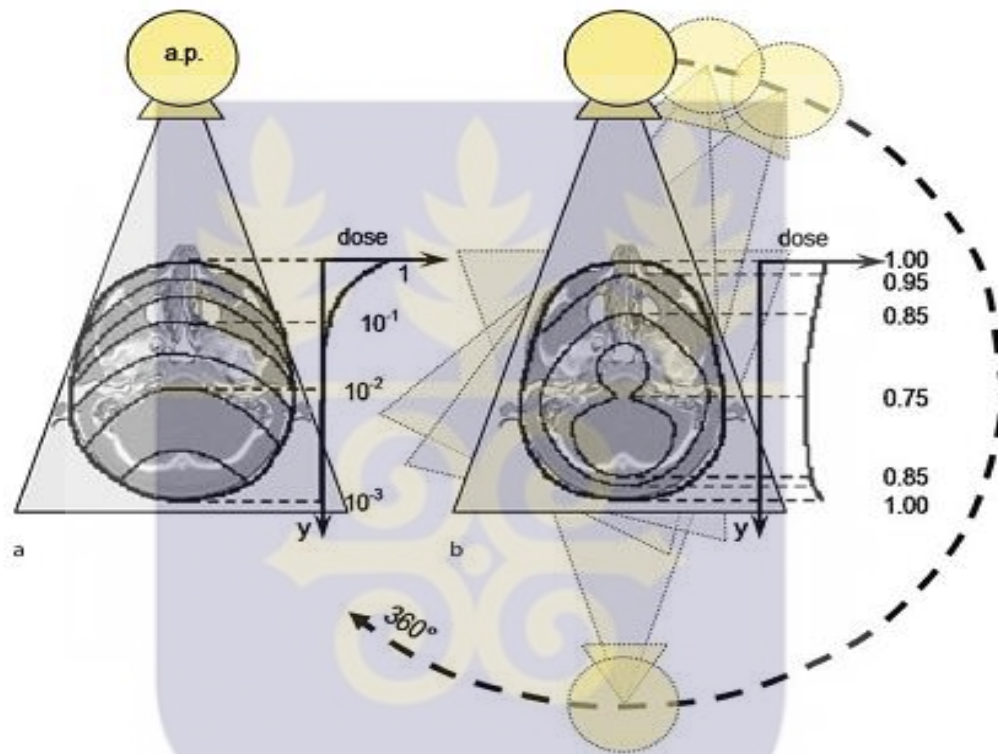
Spatial dose distribution in projection radiography (a) and 360° CT (b)
